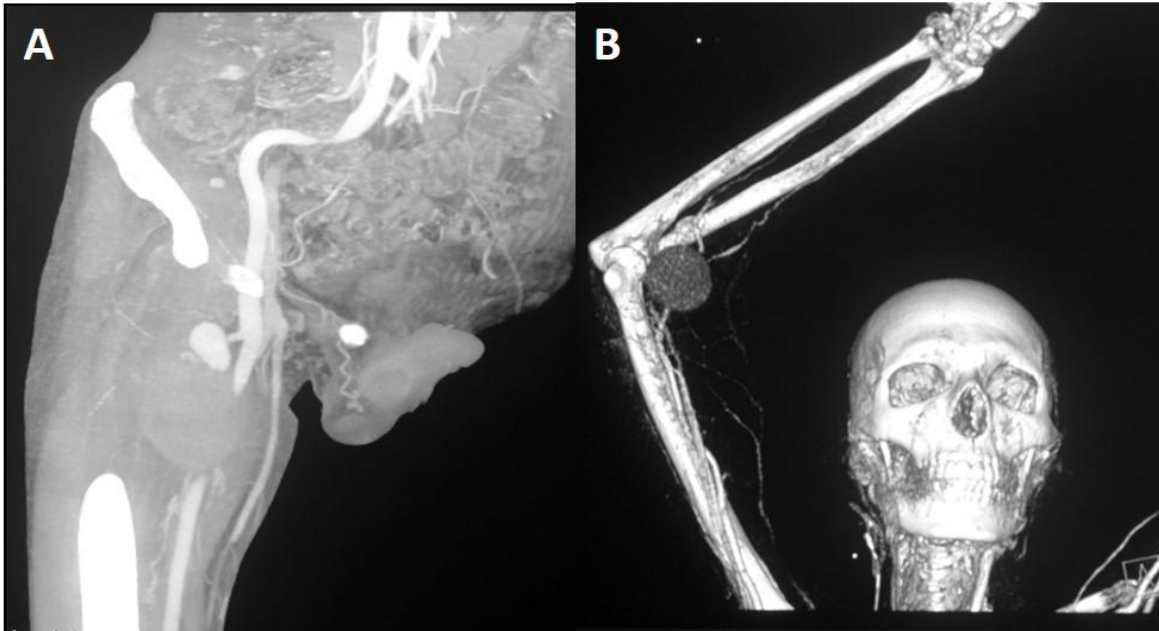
Computed tomography scan (CT-scan) showing: (A) pseudoaneurysm arising from the branch of profunda femoris artery; (B) pseudoaneurysm at elbow site.
